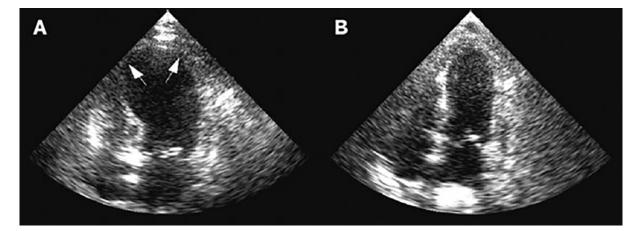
A – Echocardiograph showing dilatation of the left ventricle in the acute phase (of TS); B – Resolution of left ventricular function on repeat echocardiograph six days later⁸
